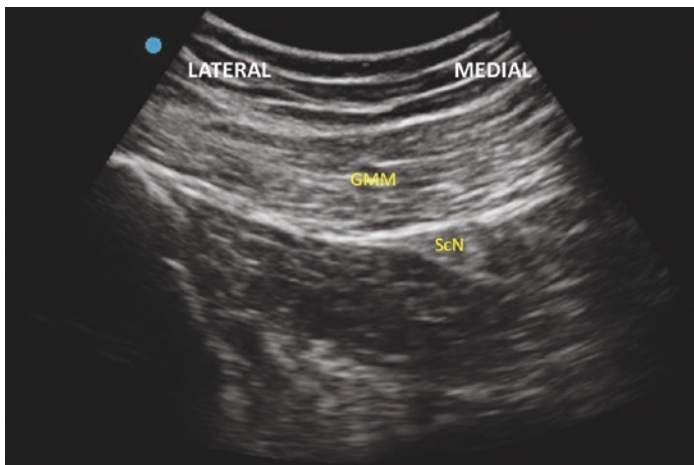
Sciatic nerve (subgluteal approach) ultrasound. The Sciatic Nerve (ScN) is positioned deep to the gluteus maximus muscle (GMM)
